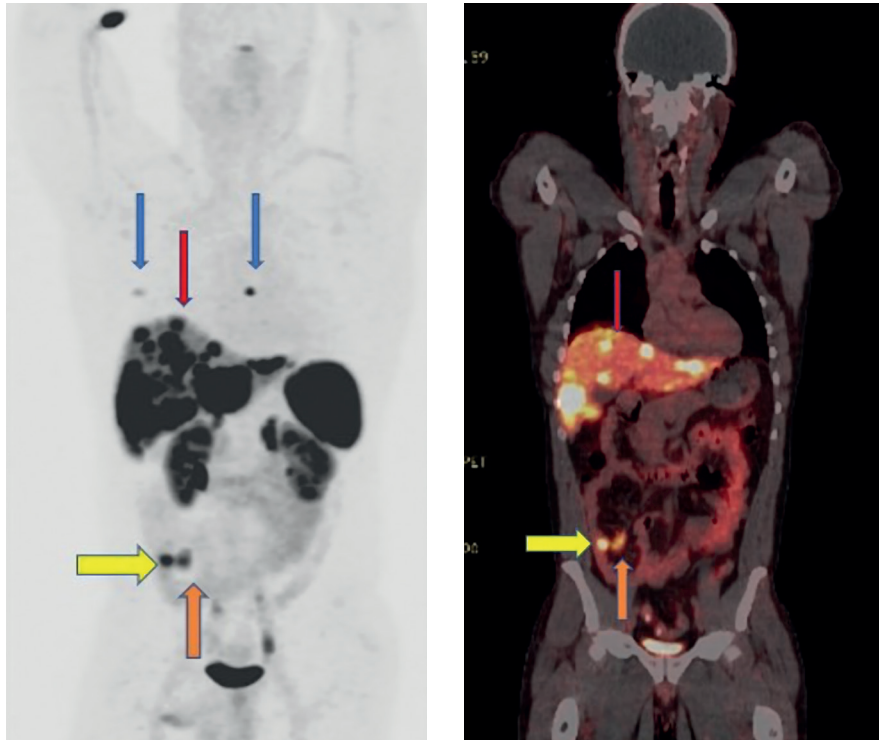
Same patient re-staged with $[^{68}\text{Ga}]\text{Ga-DOTA-TOC}$ PET/CT. 90 minutes PET/CT (a- MIP; b-fused coronal, c- fused axial and d- fused sagittal) with areas of increased uptake of tracer $[^{68}\text{Ga}]\text{Ga-DOTA-TOC}$ with higher number of liver metastases (red arrows) identifying primary small bowel tumour (horizontal yellow arrow) with mesenteric node (vertical orange) and bone metastases (vertical blue arrow) that were not detected on the Octreoscan® SPECT/CT, figure 3. Courtesy of the Department of Nuclear Medicine, The Christie NHS Foundation Trust, Manchester.
